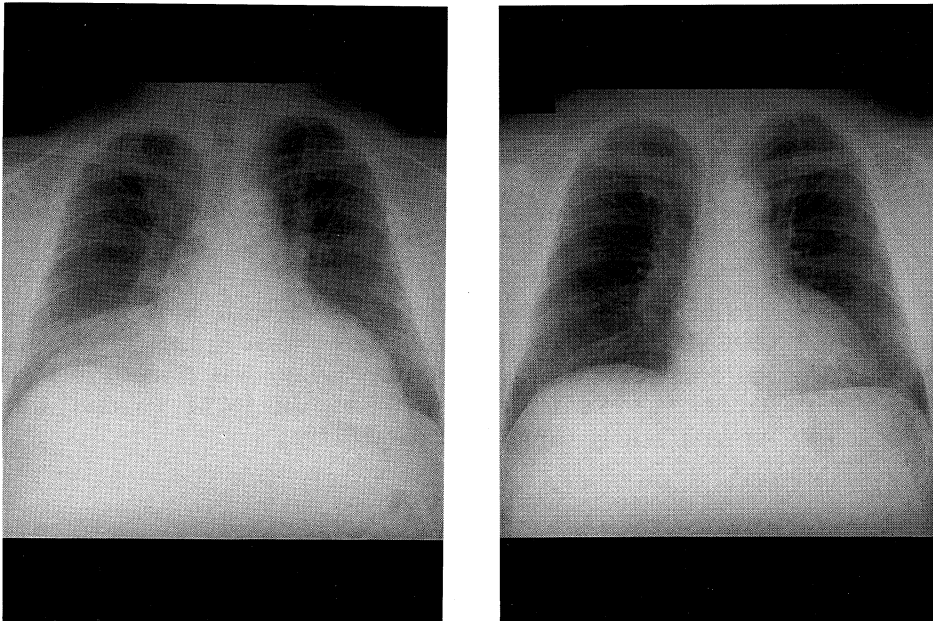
Left: A Chest X-ray film on admission showing a cardiomegaly and a right mediastinal mass adjacent to the right heart border (arrow).
